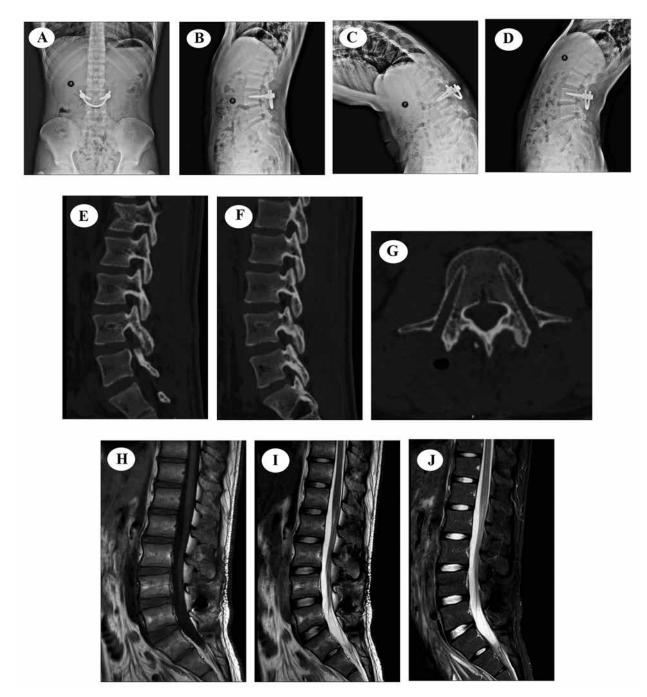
The imaging for the patient 3 years after the operation. No instability with dynamic motion can be seen in the plain radiographs (A, B, C, and D). No obvious change can be seen at the bilateral pars after the internal fixation was removed (E, F, and G). MRI still indicates no obvious lumbar disc degeneration (H, I, and J).
